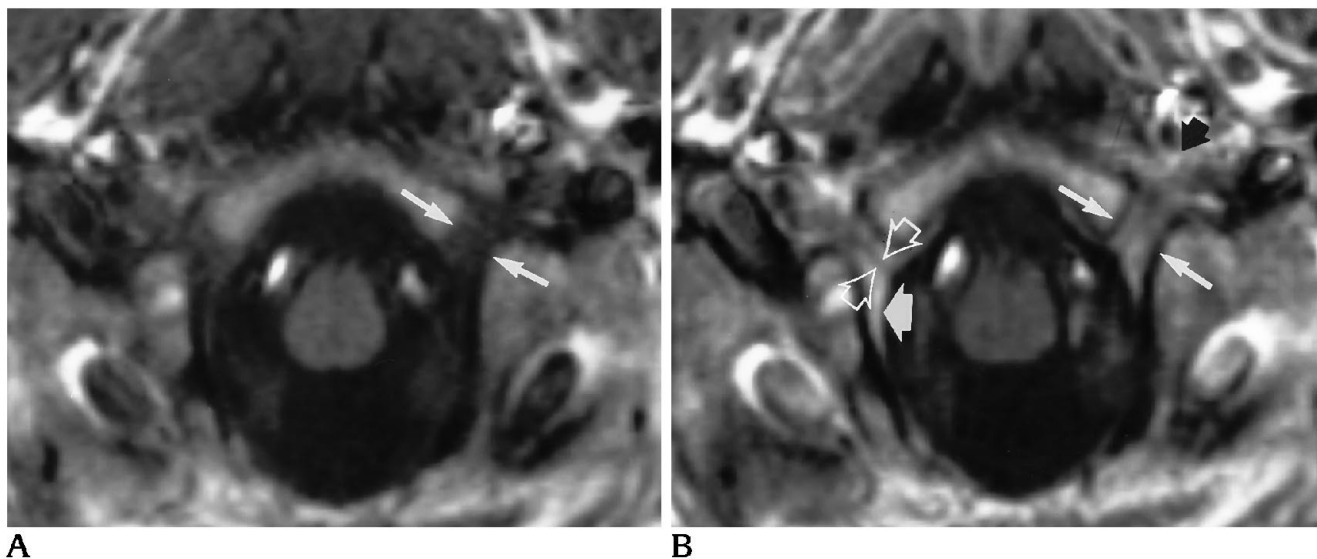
Normal hypoglossal canal. *A*, Spin-echo T1-weighted, 600/15/3 noncontrast axial image of the low posterior fossa. Note the margins of the hypoglossal canal (*arrows*).
